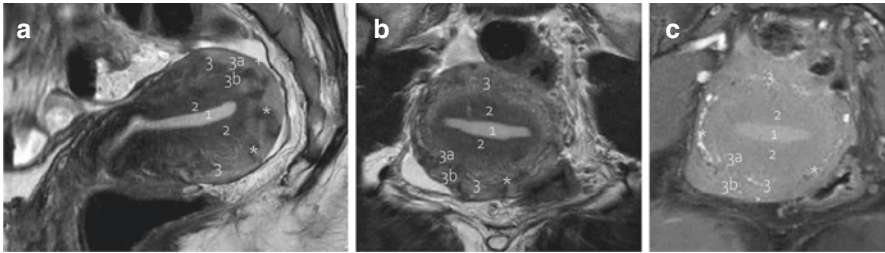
Zonal anatomy of the uterus in MRI. T2W turbo spin echo (a, b), T1W with fat suppression (c), depicting a retroverted uterus of a 38-year-old woman. (a) Sagittal plane. (b, c) Coronal plane. (1) (Eutopic) endometrium, (2) junctional zone (JZ), (3) outer myometrium, (3a) middle myometrium, (3b) outer myometrium. *Arcuate veins. +Uterine serosa
